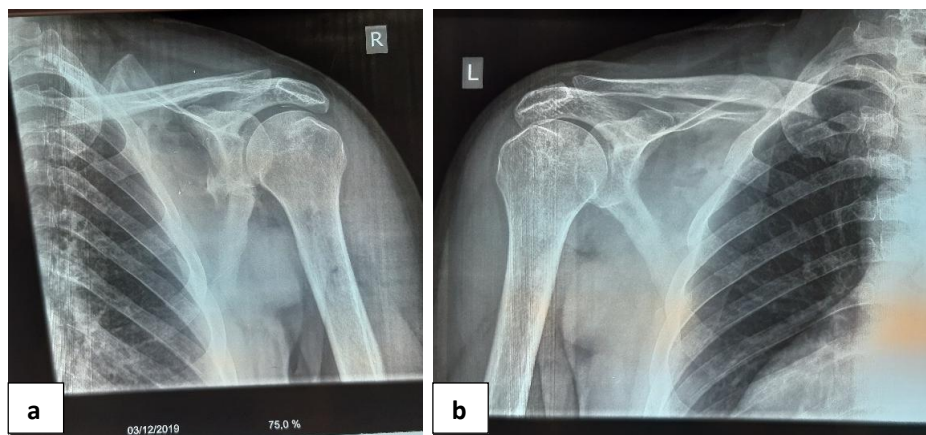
a, b frontal X-ray after 8 months of follow-up showing the consolidation of the fracture of the right shoulder (a) and the left shoulder (b)
